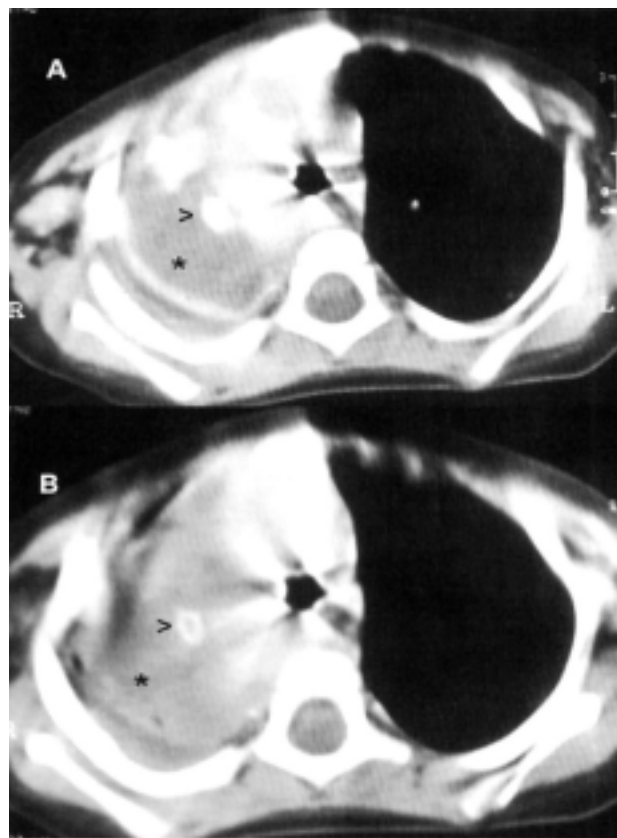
Thorax CT scan: the arrow shows the goretex graft; the asterisk points the serinoma.
